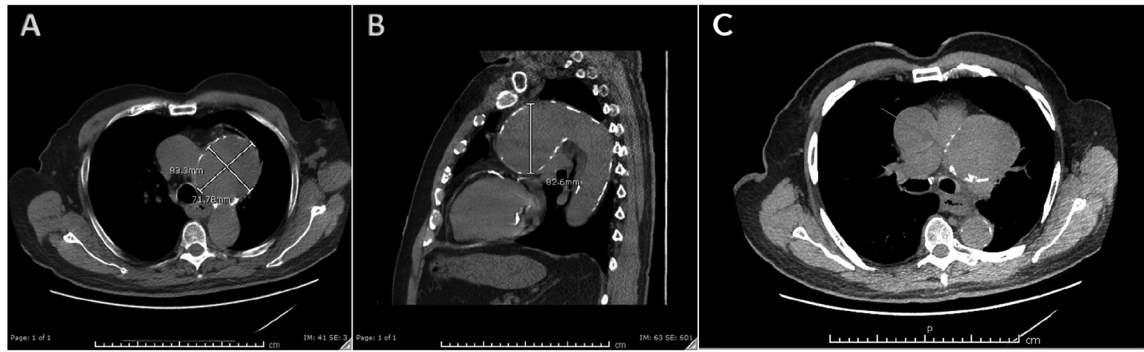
Non-contrast Computed Tomography Scan of the Chest. The axial view (A) and the sagittal view (B) show the 8.3-cm-diameter saccular aneurysm extending from the lateral anterior aspect of the aortic arch. Another axial view (C) demonstrates pulmonary vascular compression.
